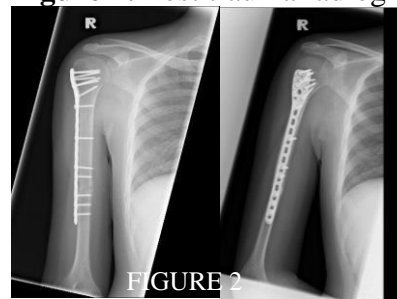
Post fixation radiographic imaging
